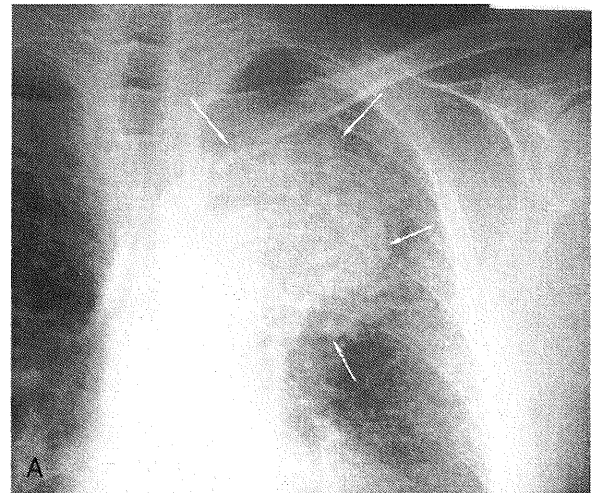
The air-space consolidation type. A, Posteroanterior chest radiograph shows pneumonialike infiltrative shadow (arrow) in the left upper lobe. The outer contour of the aortic arch was silhouetted out by the abnormal infiltrative shadow (a 69-year-old man c-T2N2M1c-stage ED). B, Contrast enhanced slightly narrowed pulmonary vessels (arrows) within the area of consolidation were noted on mediastinal window setting. C, 2 mm collimation HRCT image showed poorly marginated air space consolidation with cystic change like air-bronchiogram (arrowheads) on lung window setting. Severe emphysematous change and mild reticulo-nodular shadows representing interstitial pneumonitis were also observed.
